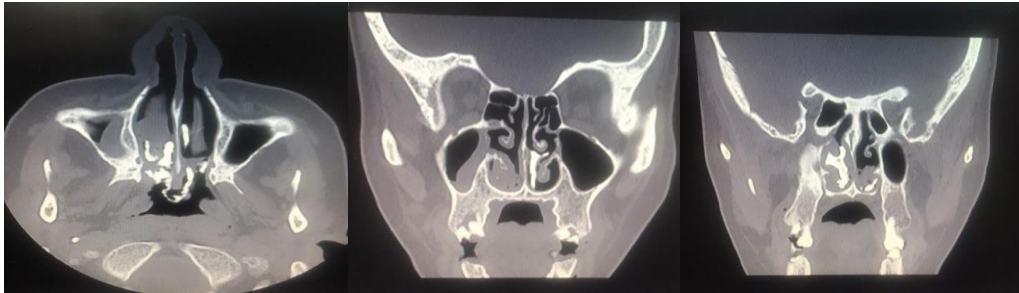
Paranasal computed tomography in axial and coronal sections shows an irregular calcified mass in both nasal cavities with mucosal thickening of the right maxillary sinus.
